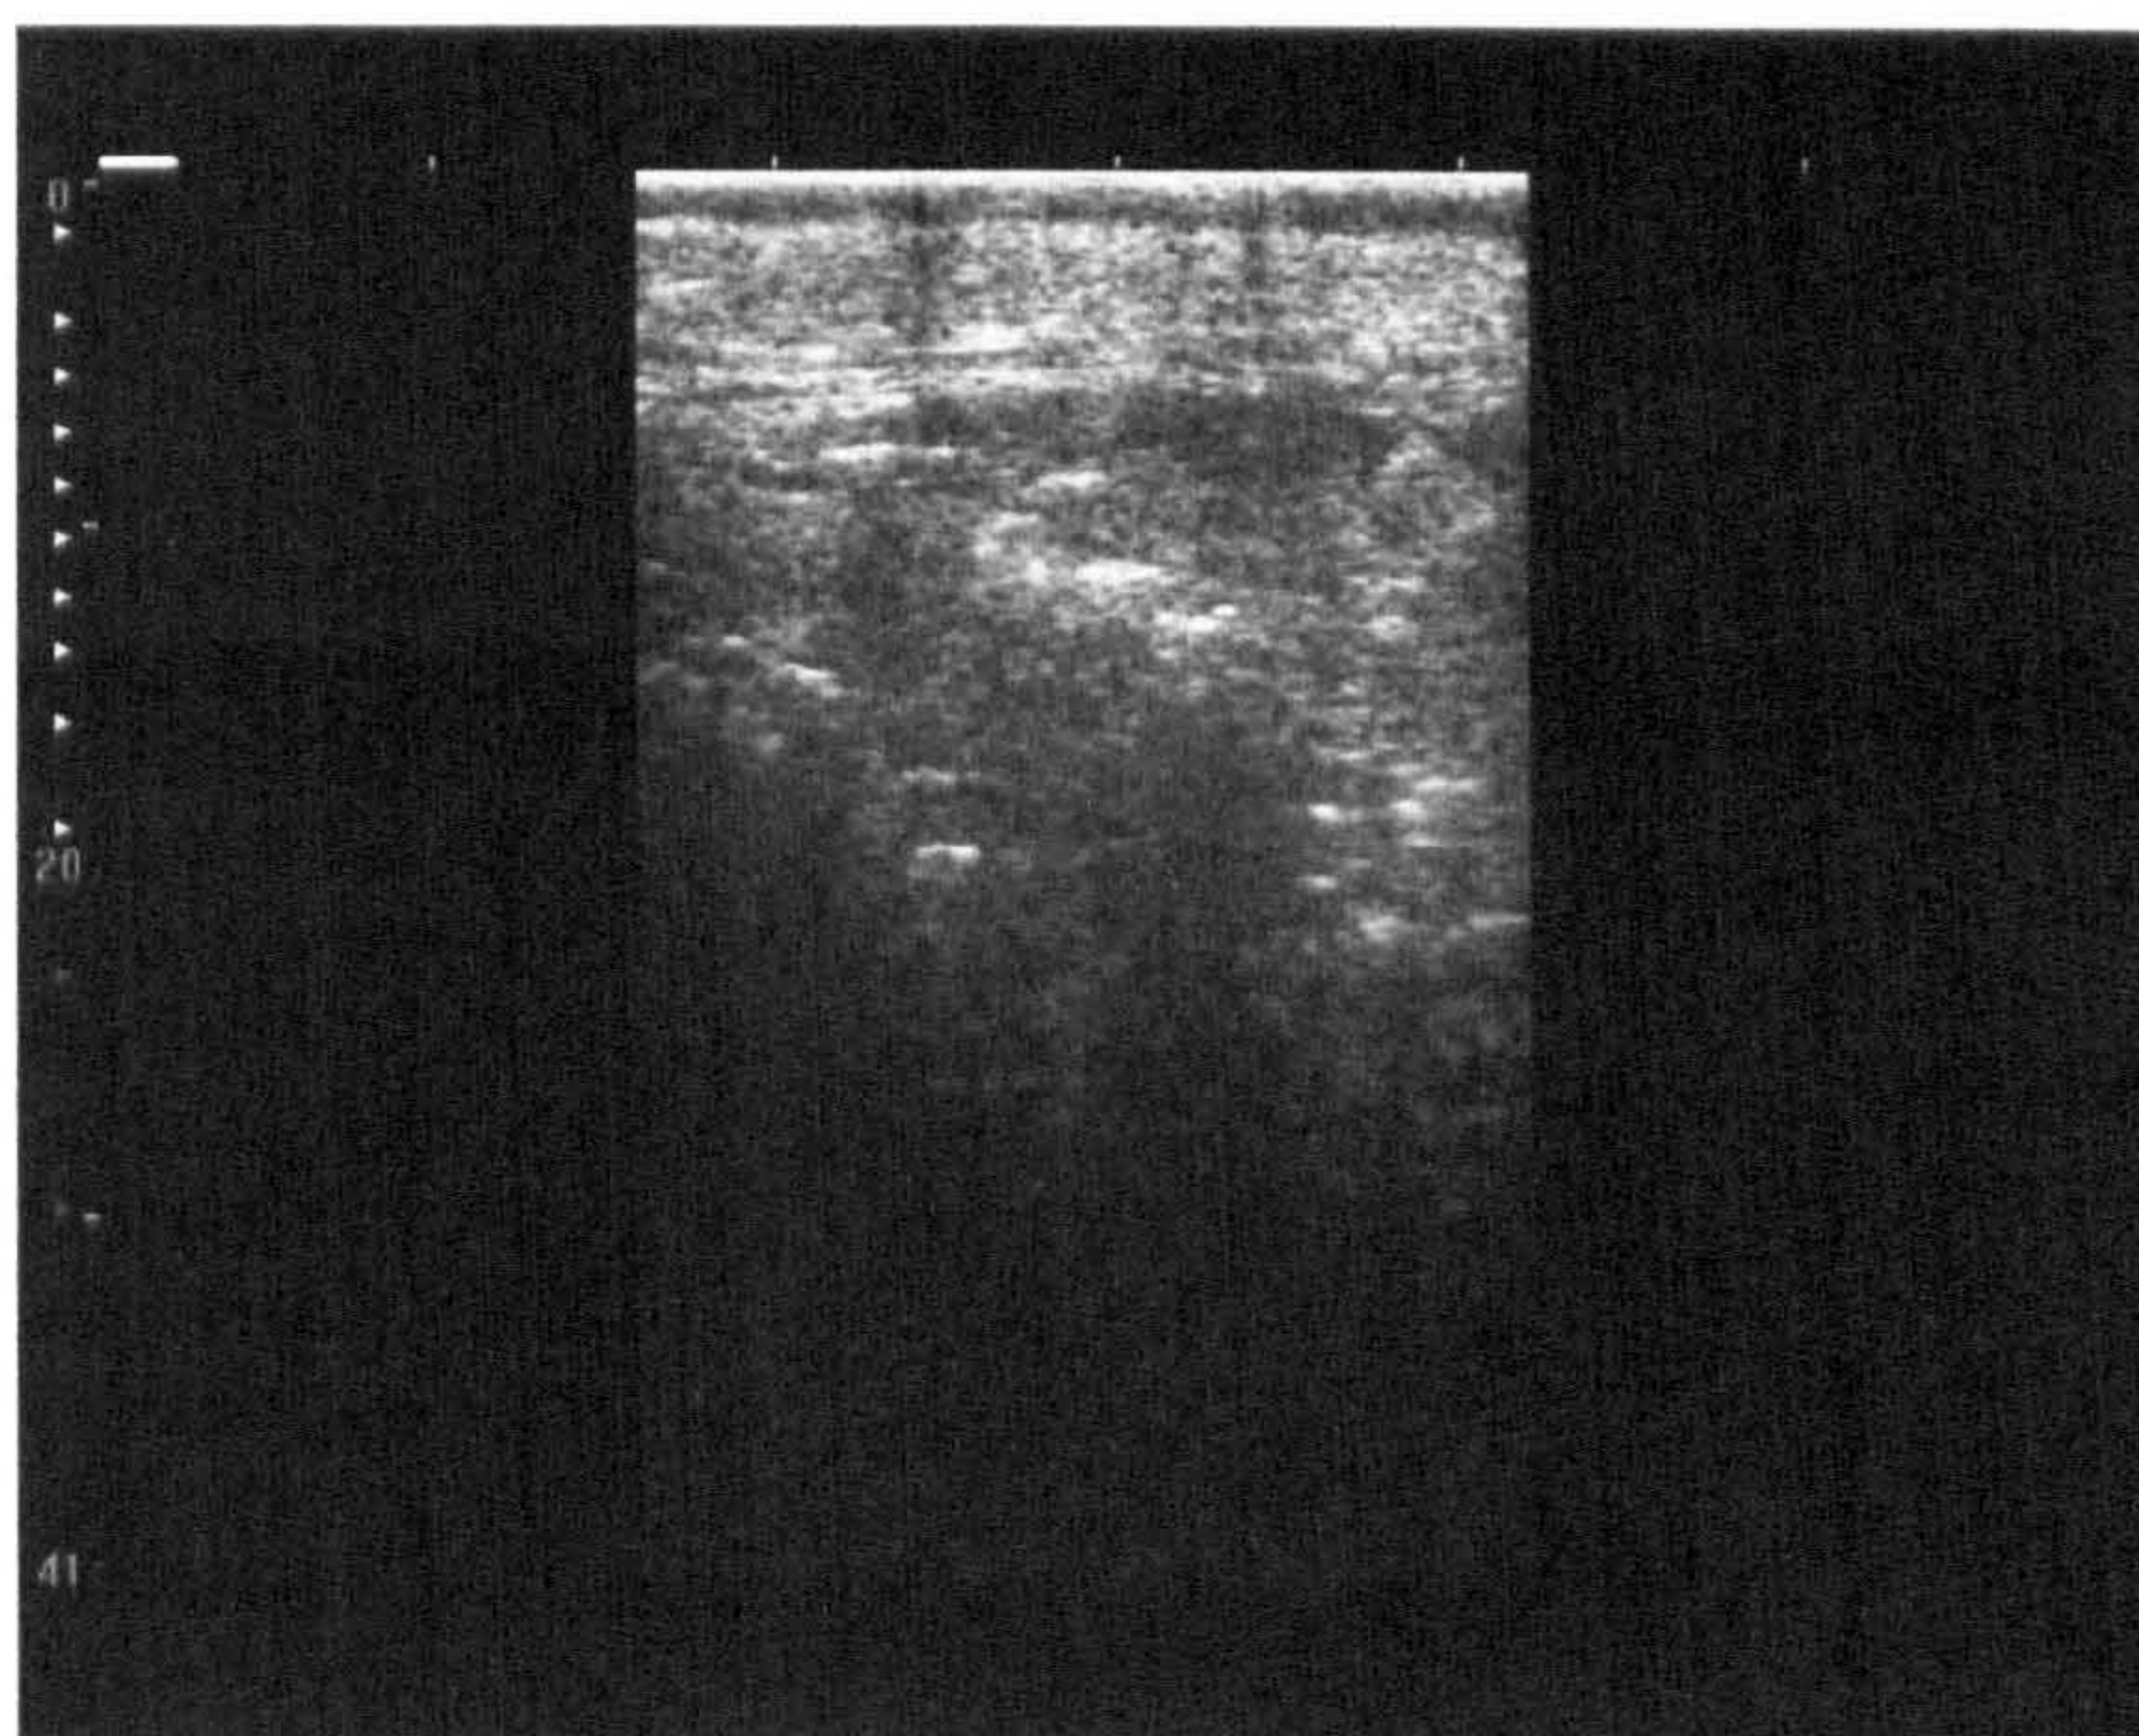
Ultrasound image of cadaver neck section
